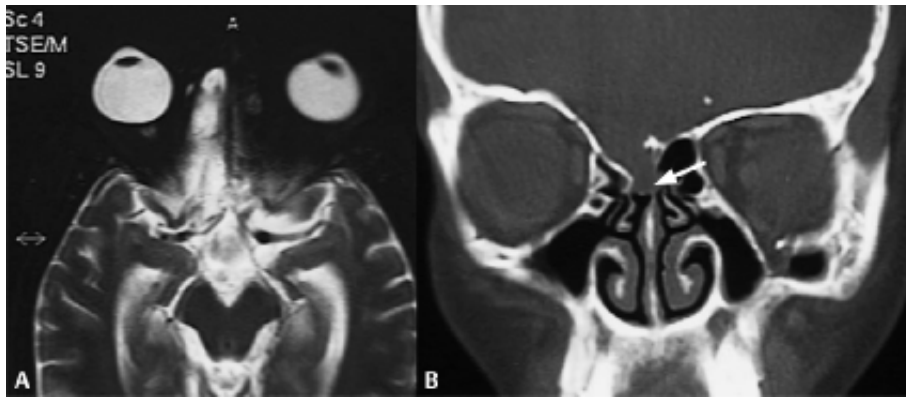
A Axial T₂-weighted MRI. Bright signal from trapped CSF. B Coronal CT. CSF fistula (red arrow) at the cribriform plate.
